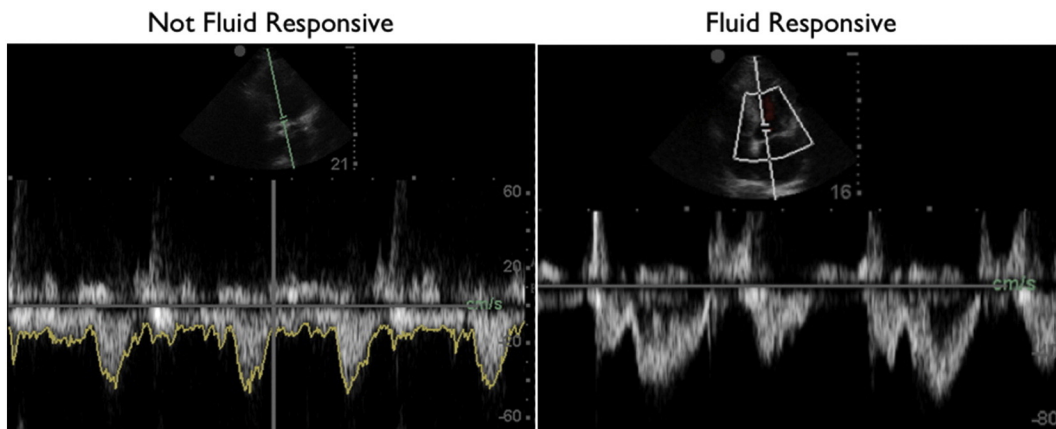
Spectral pulsed-wave Doppler tracings in nonfluid and fluid responsive states. Spectral pulsed-wave Doppler tracings of blood velocities through the LVOT in patients that are not fluid responsive (left) and fluid responsiveness (right). Note that each peak represents a set of velocities for 1 systolic cycle. Nonfluid responsiveness peaks do not vary in velocities with respiratory variation, whereas fluid responsiveness peaks do vary in velocities with respiratory variation.
